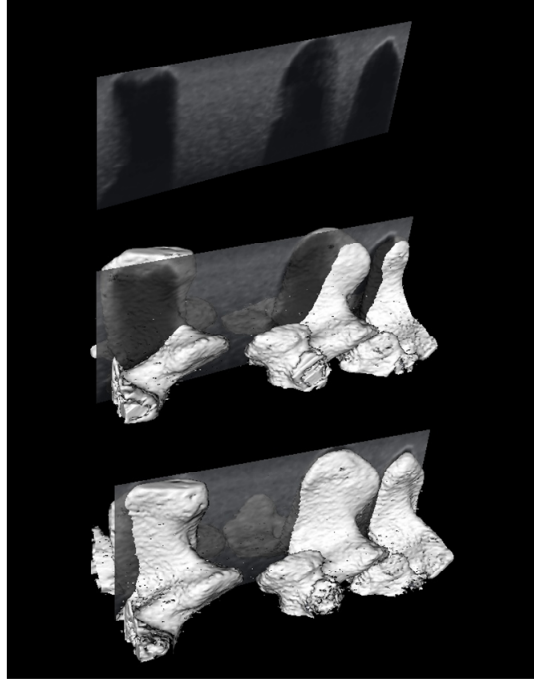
A sagittal slice from the US volume (Top) overlaid on the extracted surface of an example misaligned (Middle) and registered (Bottom) CT volume, using rigid volume-to-volume registration.
